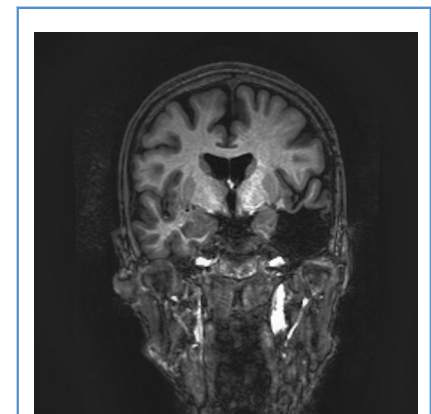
Coronal T1-weighted magnetic resonance imaging shows in the inferior temporal lobe that the very posterior portion of the temporal fusiform gyrus may be intact. The superior temporal cortex appears to exist from the position of the anterior end of the amygdala. The left hippocampus appeared healthy indicating that it was well functioning.
